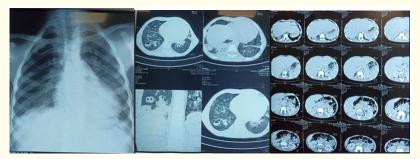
Frontal lung X-ray: Right basal cystic image, rounded, fairly well defined, confluent and with thickened walls, the CT complement Cross-sectional image shows rounded lucency at the apical level of the right lung bronchopneumopathy with diffuse excavated pulmonary nodules.
